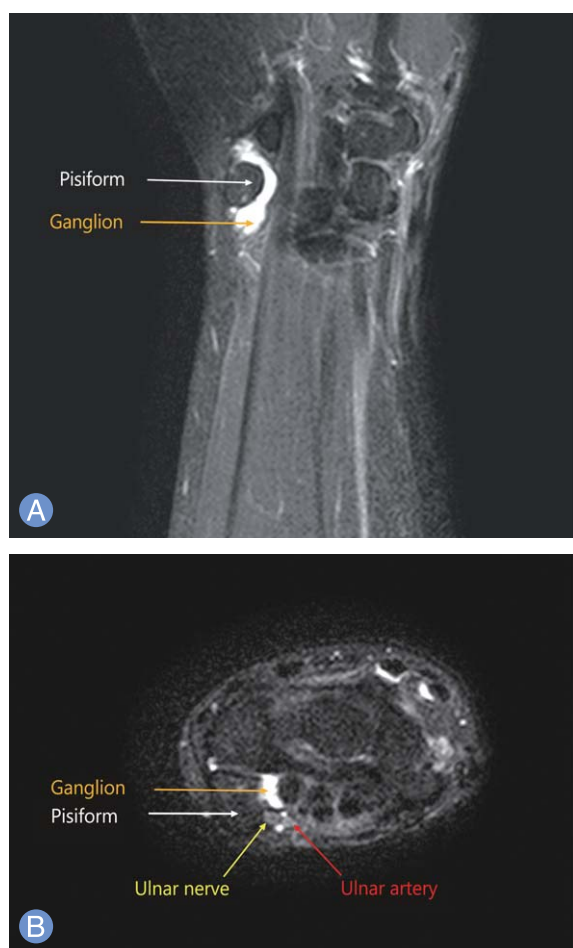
Magnetic resonance imaging of Guyon's canal. A dumbbell-shaped ganglion at the pisotriquetral joint volarly abutting the ulnar nerve at Guyon's canal was observed. (A) T2 fat suppression coronal image. (B) T2 fat suppression axial image.
